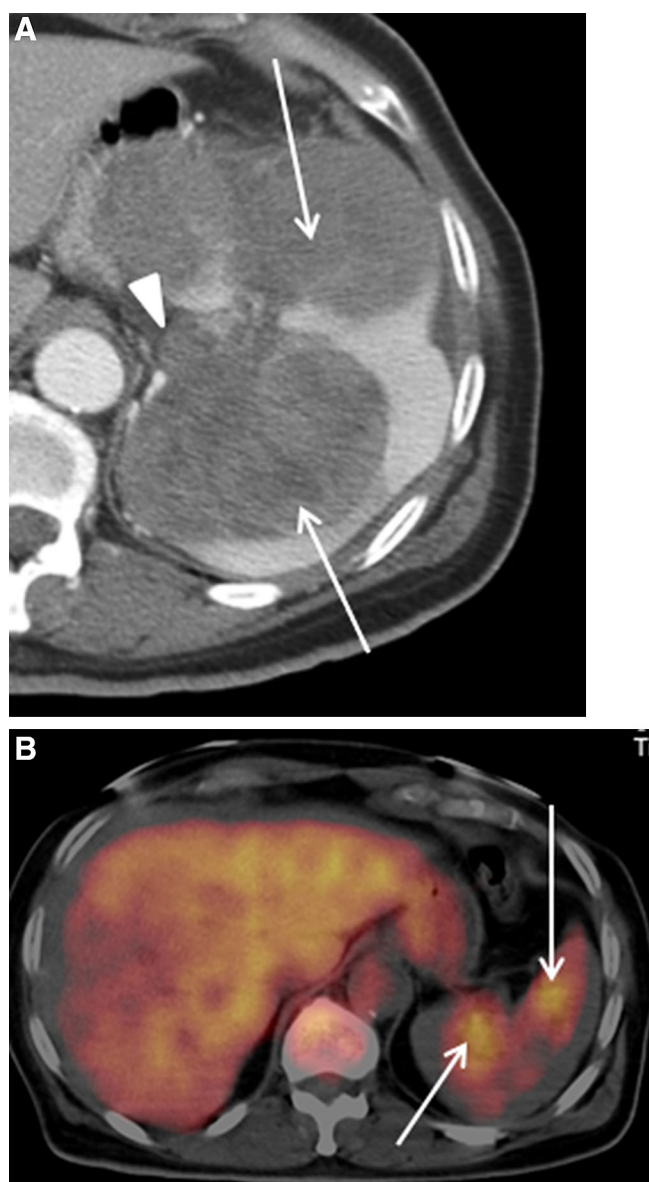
Splenic lymphoma. 68-year-old with splenic lymphoma. A Axial contrast-enhanced CT image shows large, lobulated, heterogeneous hypodense masses (arrows) in the spleen. Apart from a few enlarged perisplenic hilar lymph nodes (arrowhead), no other enlarged distal thoraco-abdominal nodes were seen. Ultrasound guided biopsy-confirmed primary splenic lymphoma. B Axial ^{18}F FDG PET/CT at 6-month post chemotherapy follow up confirms treatment response, but with residual disease in the spleen manifesting as areas of increased ^{18}F FDG uptake (arrows).
